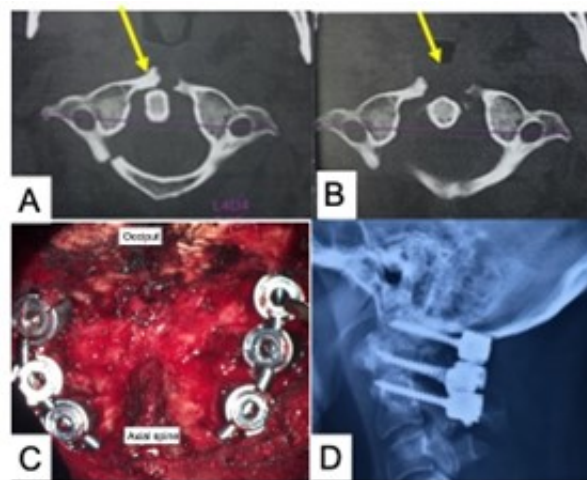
(A) CT scan of CVJ showing Jefferson fracture; (B) CT scan after 6 weeks showing unstable fracture; (C) perioperative picture of fixation of the occipital condyles (Co), C1 lateral mass, and C2 lateral mass with fusion for unstable Jefferson fracture; (D) postoperative X-ray showing fixation of Co-C1-C2. Source: Figure by authors.
